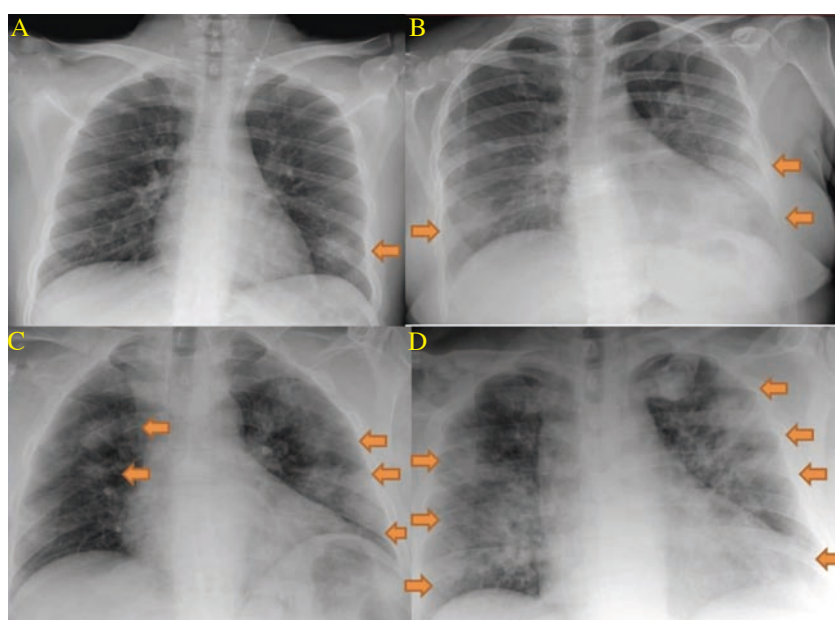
Chest X-ray scoring system. Examples of chest X-ray severity scores in patients with COVID-19 (right lung scores + left lung scores = total scores, one yellow arrow refers to 1 point): A: 0+1=1. B: 1+2=3. C: 2+3=5. D: 3+4=7.
